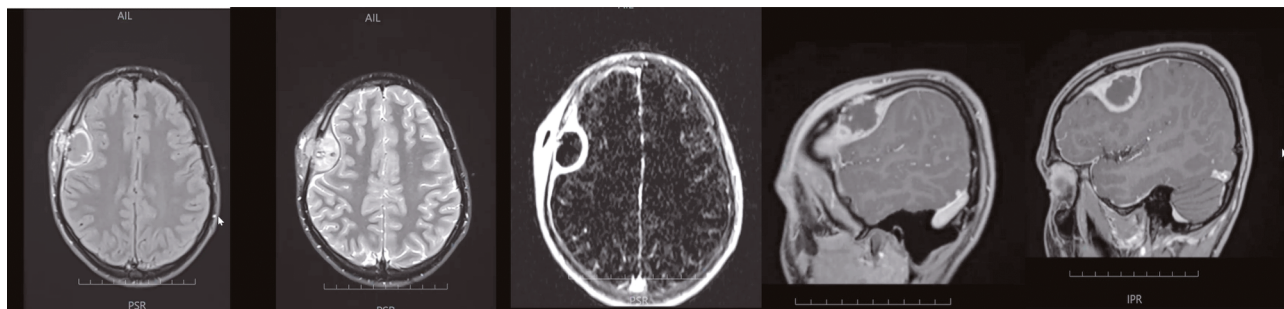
Brain MRI, axial and sagittal planes. Right parietal osteolytic lesion with parasosseous soft-tissue component, intracranial extension, and parameningeal involvement of the frontal and parietal regions
